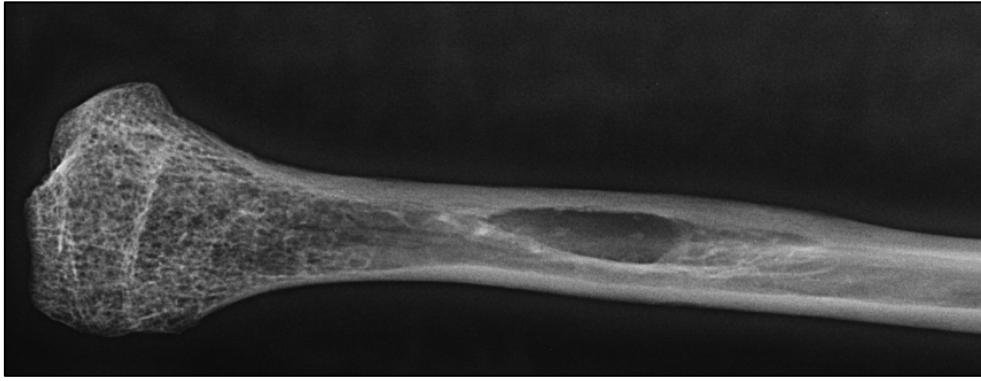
Radiograph of osteolytic lesion consistent with a “Brown tumour” from secondary hyperparathyroidism on the proximal left fibula (AT-583, male, ~19 years. Emeel Tolgoi). Image: author’s own.
